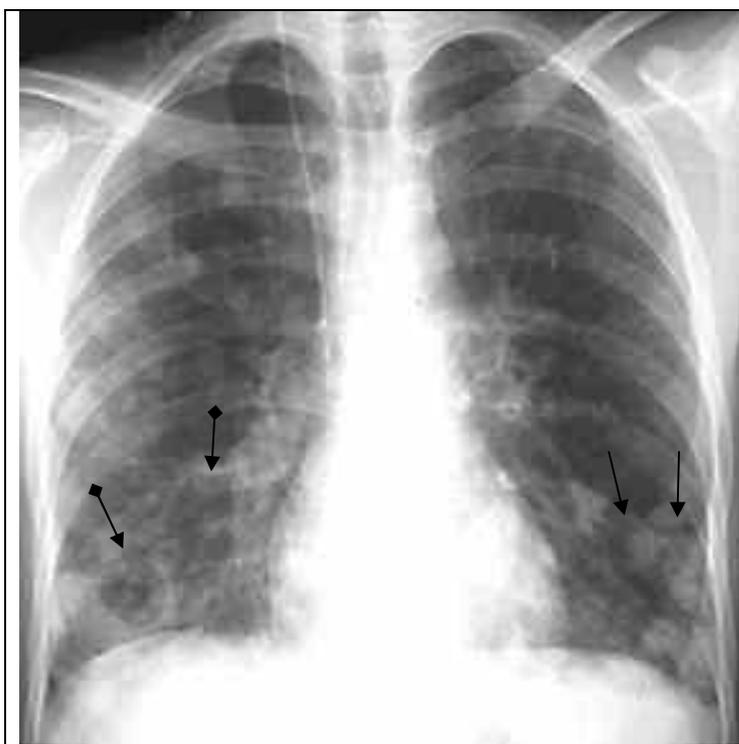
The frontal chest radiograph. Plural roundish shadows with indistinct contours in the inferior department of a pulmonary field on the left (arrows). On the right in the inferior department of a pulmonary field the limited shadow, non-uniform with indistinct contours in which there is roundish radiolucency (arrow with a rhombus). Septic pneumonia with disintegration cavities.
